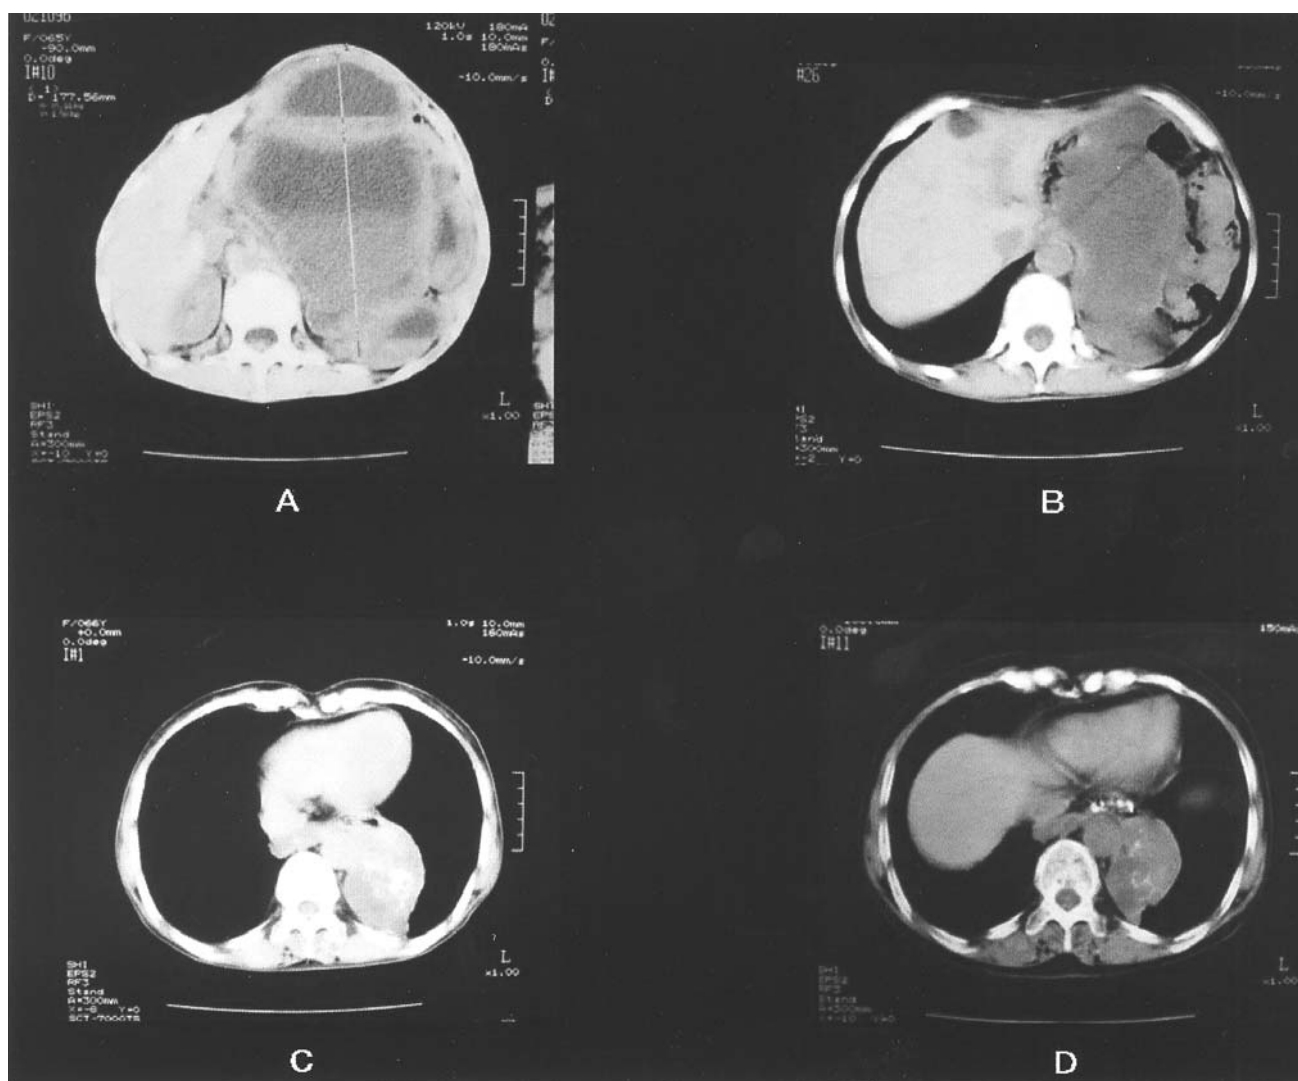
After receiving the combination therapy, CT scans of Case 2 show a gradual decrease in tumor size; from 177.56x117.65 mm on 11 July 2002 (A) to 117.65x79.41 mm on 30 October 2002 (B), and further to 70.11x55.32 mm on 7 January 2003 (C), with a final decreased to 65.34x44.23 mm on 22 July 2003 (D).
